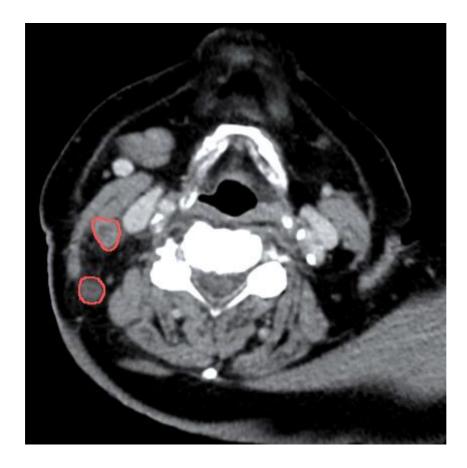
Post-operative Target Volumes and CT axial image at the level of parotid gland
